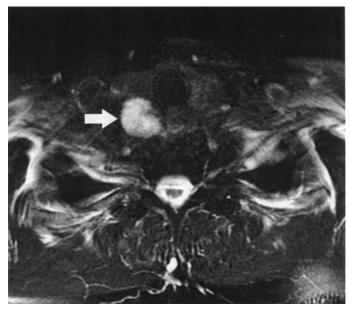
Magnetic resonance imaging of the neck of a 54-year-old man presenting with severe hypercalcemia demonstrating a 4-cm parathyroid cancer (*arrow*).
